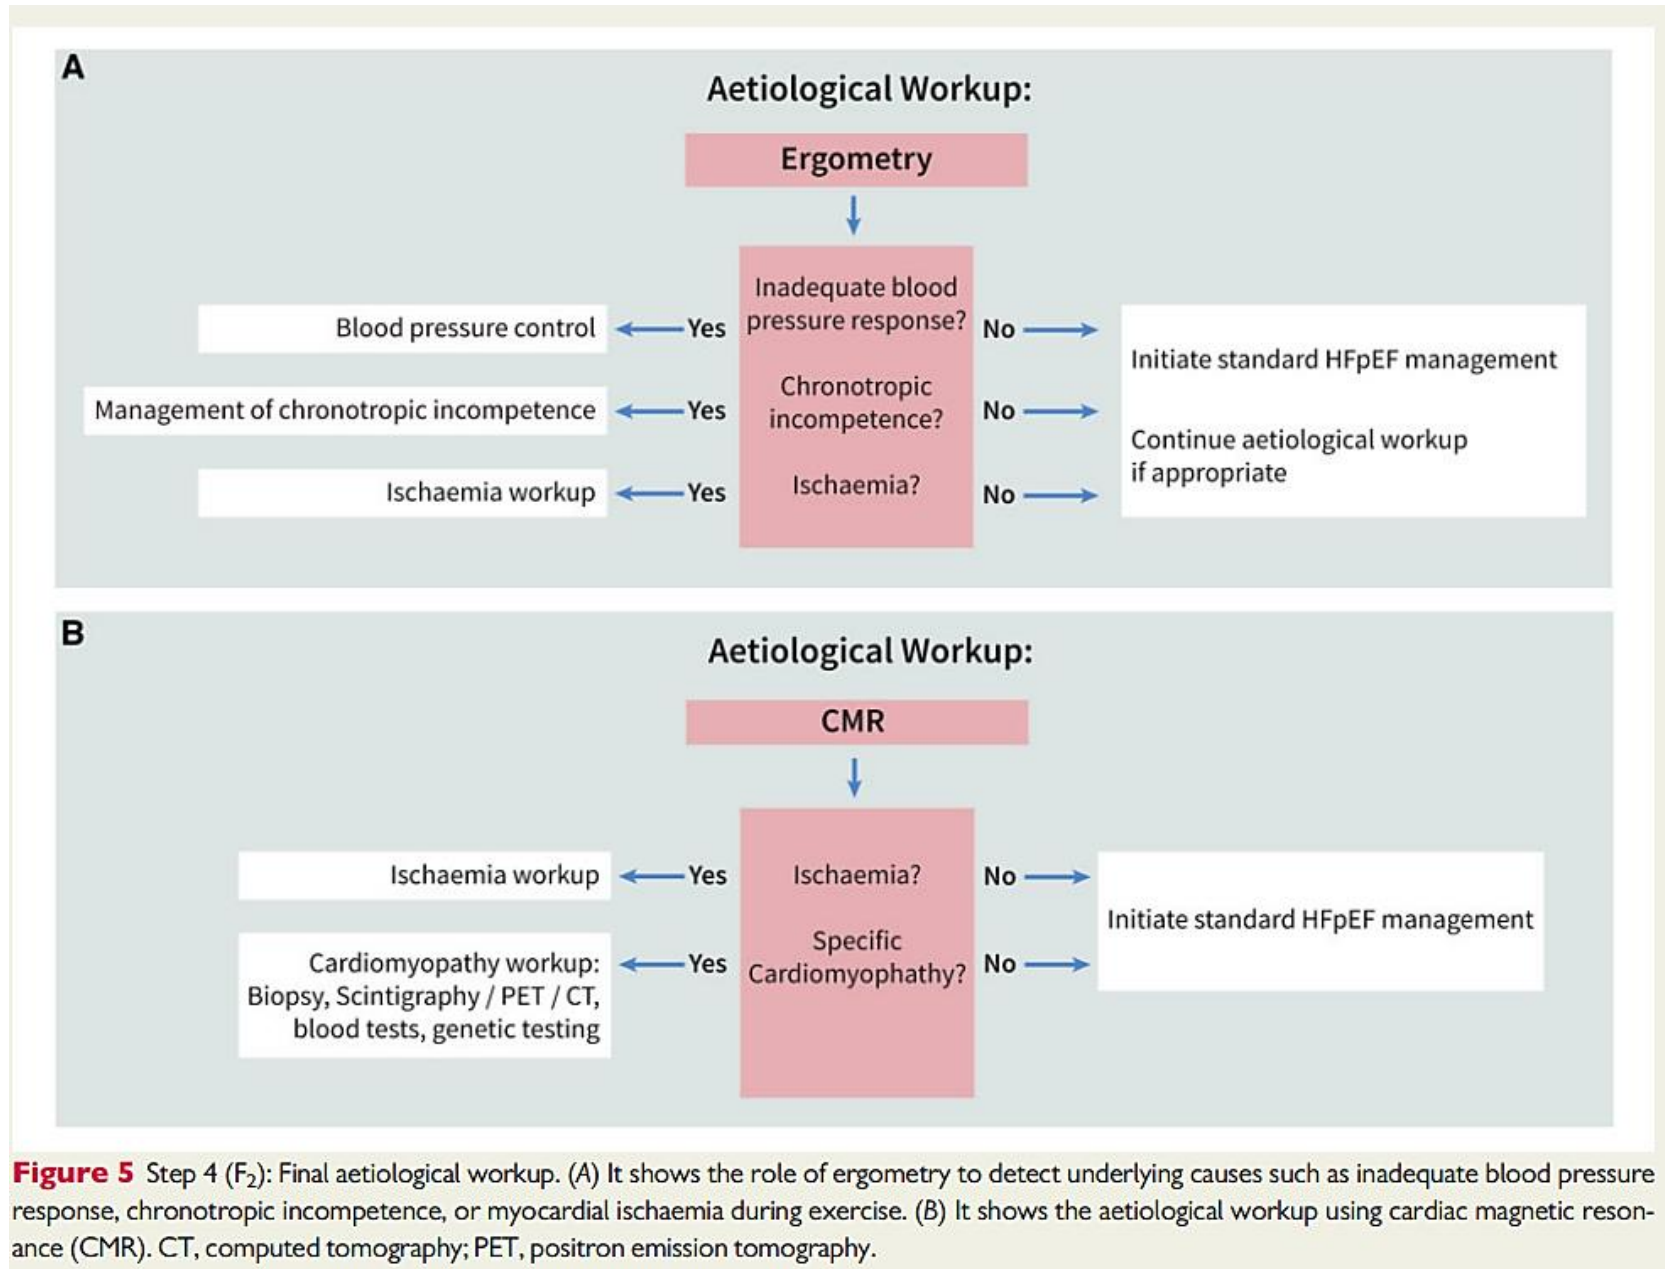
Step 4 (F₂): Final aetiological workup. (A) It shows the role of ergometry to detect underlying causes such as inadequate blood pressure response, chronotropic incompetence, or myocardial ischaemia during exercise. (B) It shows the aetiological workup using cardiac magnetic resonance (CMR). CT, computed tomography; PET, positron emission tomography.
